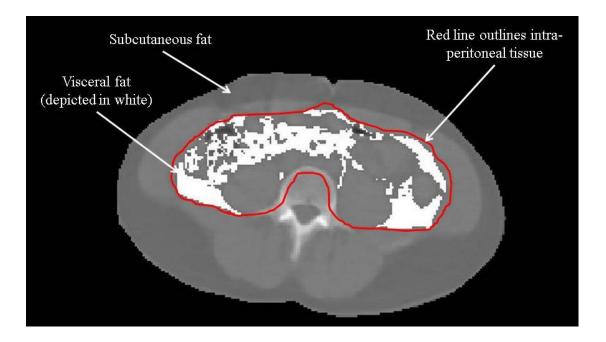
CT image demonstrating identification of visceral fat. The intraperitoneal region was defined by tracing its outline. Tissue within the intraperitoneal region with pixels having attenuation within the defined range of fat was depicted as white. Fat area was calculated by summation of the pixels in each area.
